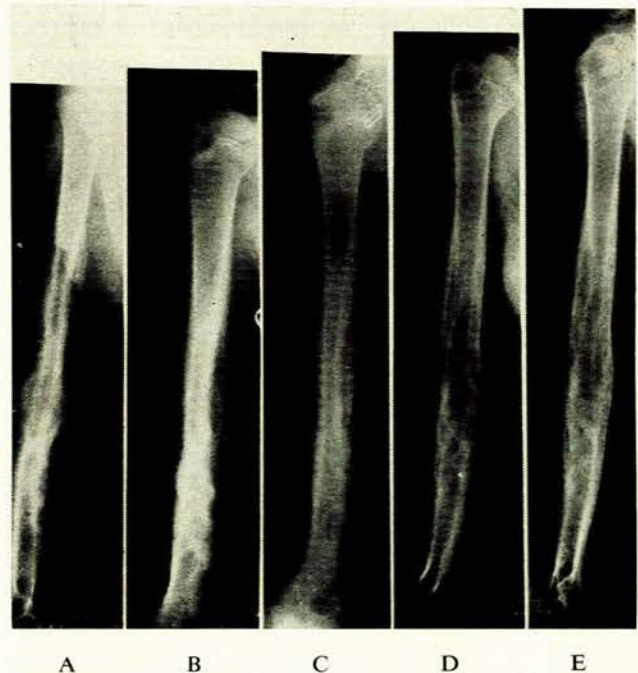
X-ray stages of response to DXT of a primary sarcoma of bone—Ewing's sarcoma.
